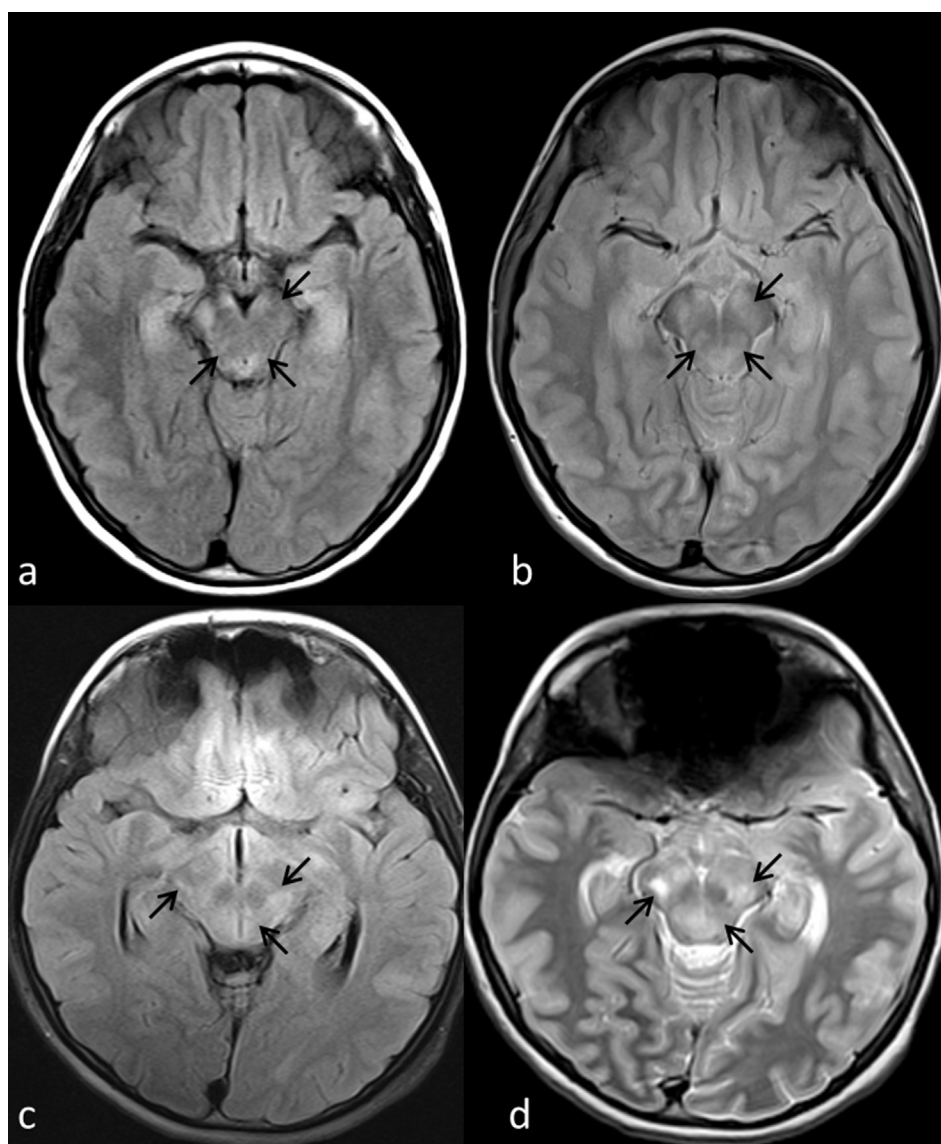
FLAIR (a + c) and PDw (b + d) images in axial orientation of two patients with NF 1: In the first patient (upper row a+b) hyperintense lesions (arrows) can be well detected in the PDw images (b) located in the dorsal parts of the midbrain as well as in the crus cerebri of the left side compared to the FLAIR images (a). In the second patient (lower row) UBOs (arrows) at the mesencephalic region are well seen in the PD images (d) and can only be suggested at the FLAIR (c) images at a second look.
